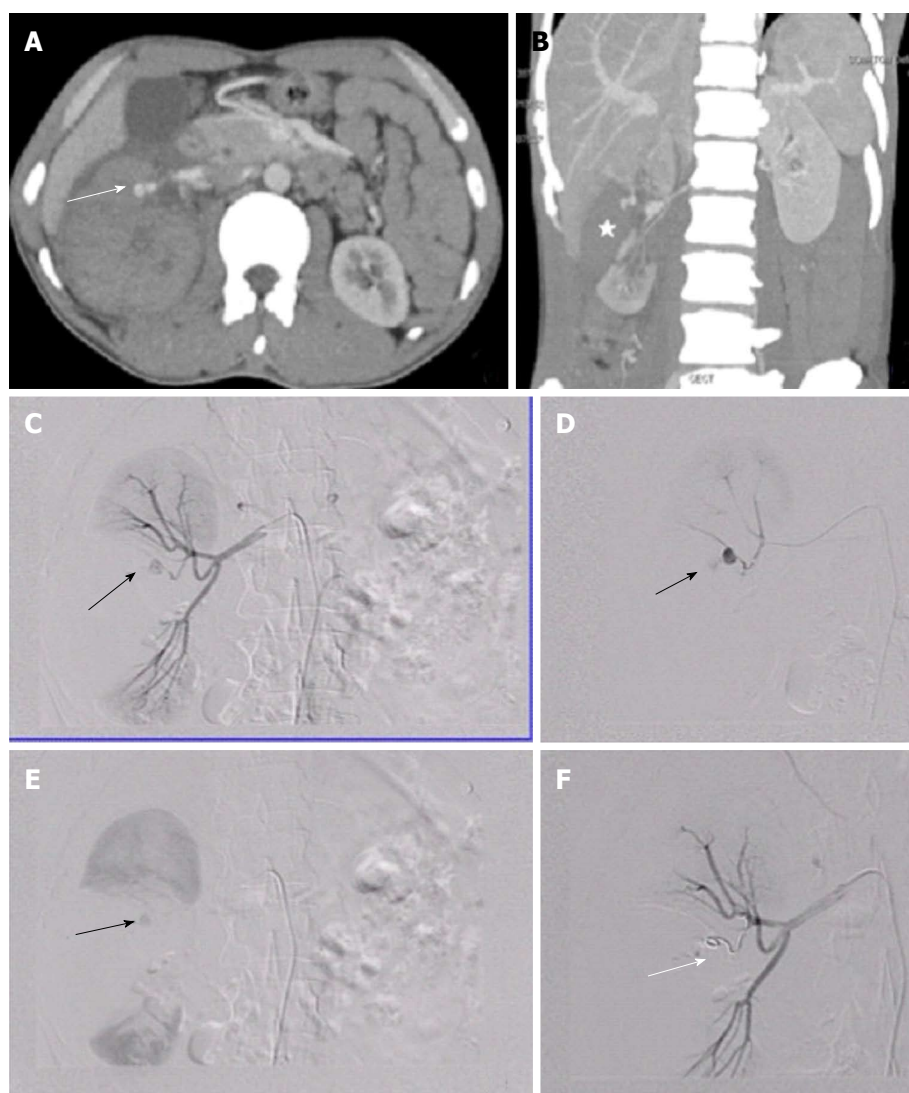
Renovascular injury: 35 years old male with blunt trauma abdomen. A, B: CECT abdomen showed deep lacerations involving the interpole of right kidney extending upto the renal hilum (asterisk). A pseudoaneurysm (arrow) was seen arising from upper polar branch along with presence of perinephric hematoma; C, D: DSA with catheterisation of right main renal artery confirmed the presence of pseudoaneurysm (arrow); E: In view of end arterial supply, involved branch was selectively accessed and catheter was subsequently manipulated across the neck of PsA with the help of microwire followed by deployment of coil; F: Post embolization angiography showed non opacification distal to the coil (arrow). CECT: Contrast enhanced computed tomography; PsA: Pseudoaneurysm; DSA: Digital subtraction angiography.
